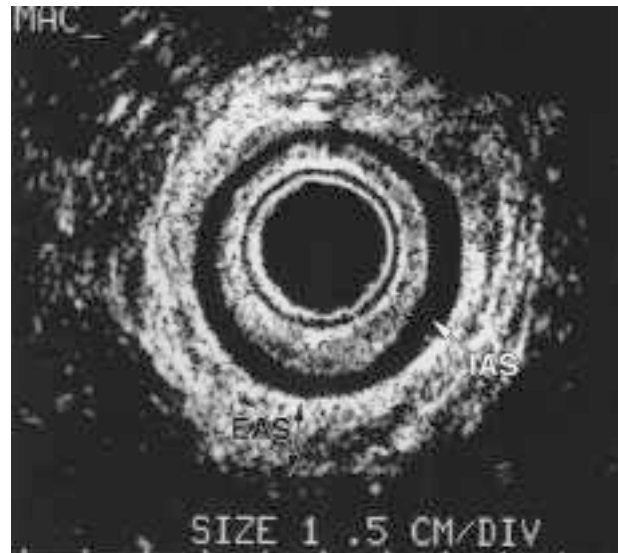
Two-dimensional ultrasound from the mid-anal canal. This ultrasound image represents normal, intact internal anal sphincter (IAS) (hypoechoic) and external anal sphincter (EAS), (hyperechoic).
